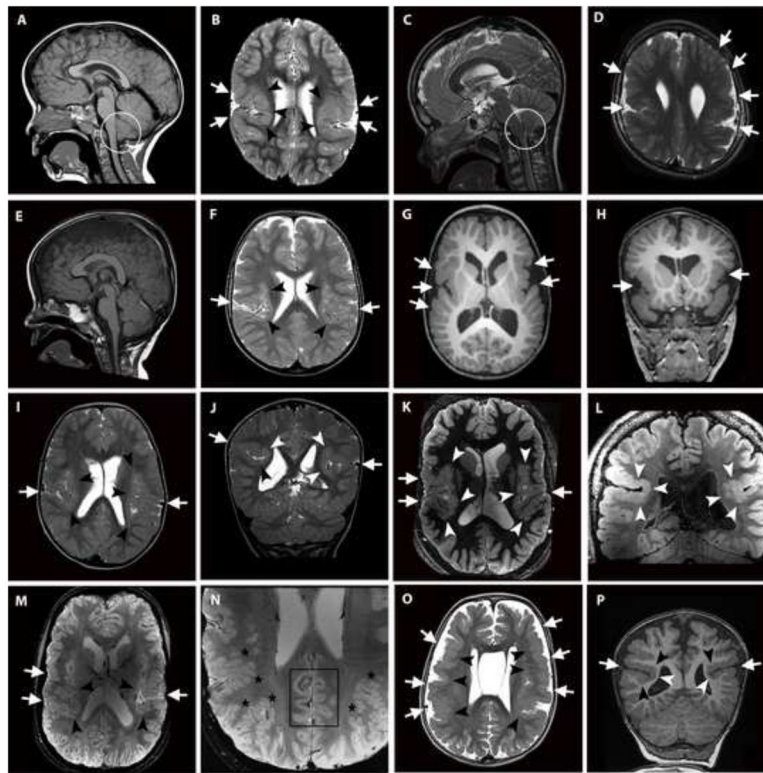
Brain MRI images of patients with mosaic *PIK3R2* mutations
